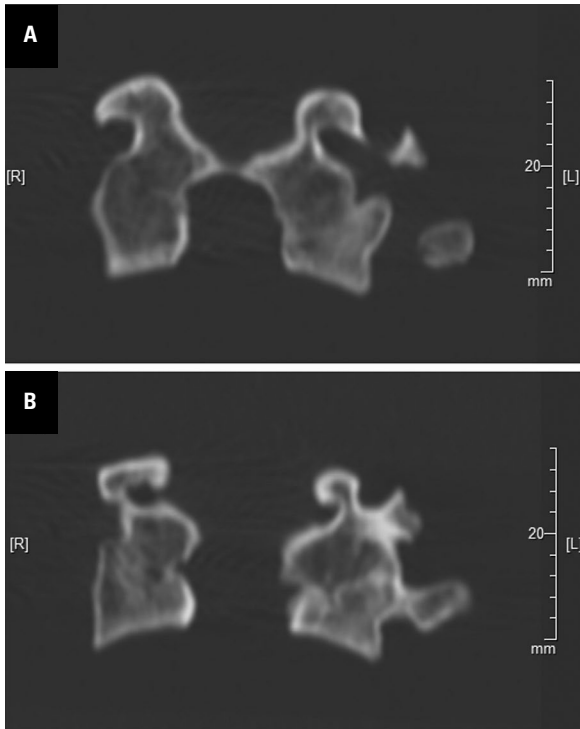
A, B. Coronal reformatted computed tomography images of the occipitalised atlas on two parallel planes.
